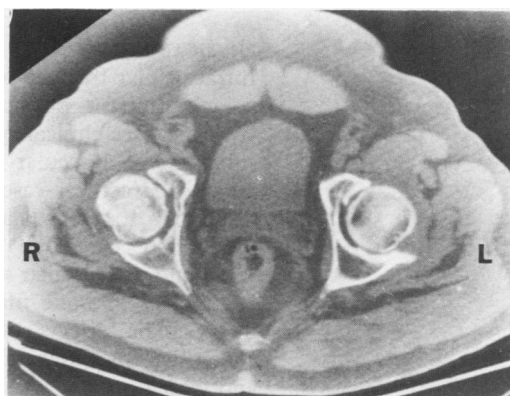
A computed tomography (CT) scan showing the irregular contour of the right femoral head after collapse of the articular surface in stage III subchondral avascular necrosis. The radiolucent line beneath the collapsed cartilage is the CT representation of the 'crescent sign' seen on plain radiographs.
